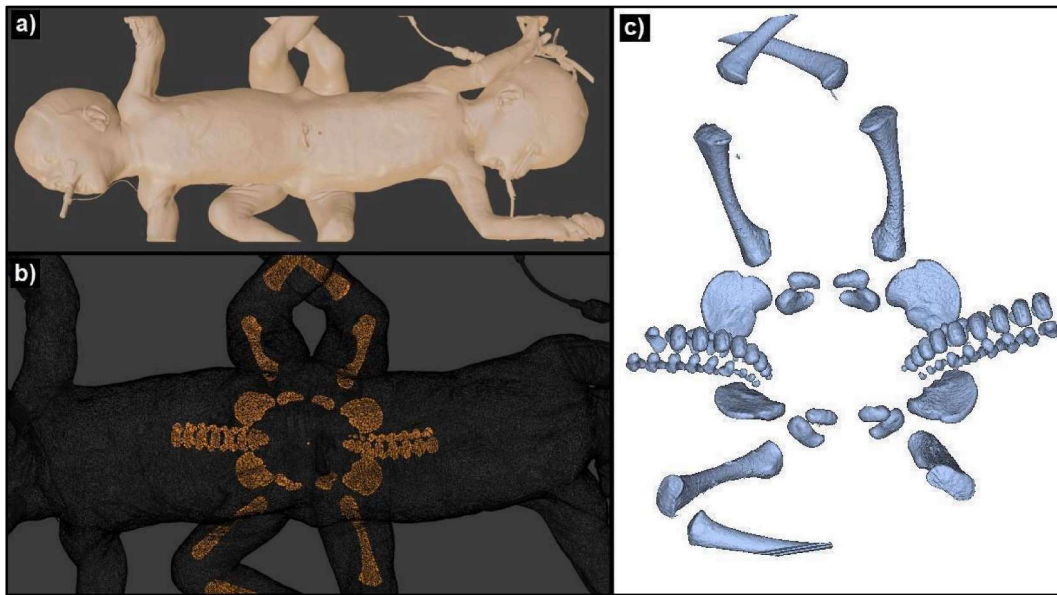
Pelvis segmentation using CT scans for 3D printing. a) 3D reconstruction of patients' bodies. b) Identification of the bony pelvis of the conjoined twins. c) Segmentation of the tissue of interest and generation of the 3D model to be printed.
